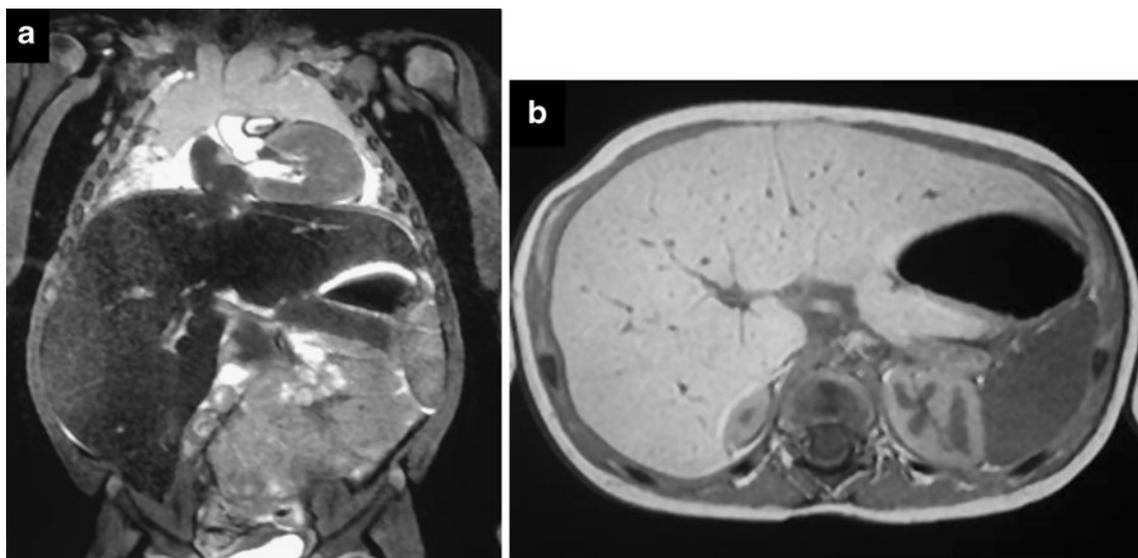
Total body post-mortem MRI. a Coronal T2-weighted sequence. Marked liver hyposignal compared with the spleen signal. b Axial T1-weighted sequence. Hepatomegaly with homogeneous hypersignal compared with the spleen signal
